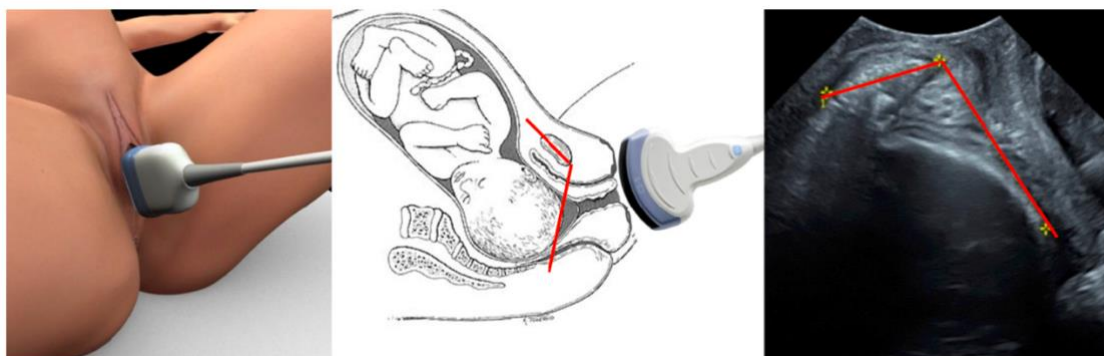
Measurement of the angle of progression *(Adapted from ISUOG Practice Guidelines: intrapartum ultrasound)* ³
